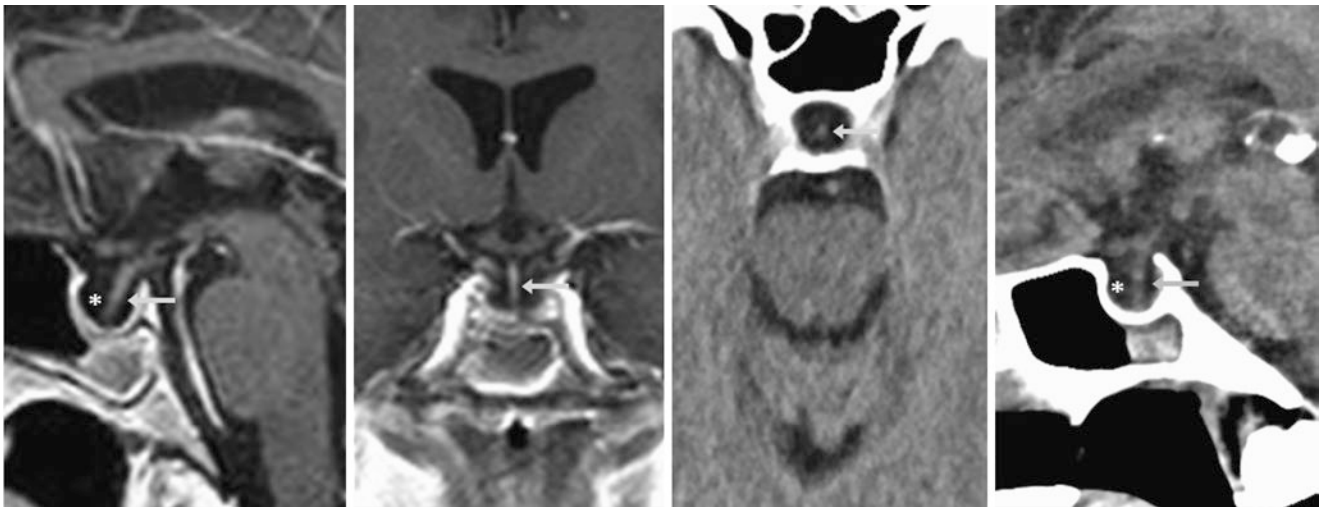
A 56-year-old female patient with confusion and an otherwise negative 1.5 T MRI had a completely empty PES (*). Note a normal stalk (*arrows*) on postcontrast sagittal (*left*) and coronal (*left middle*) T1WI. On CECT axial (*right middle*) and sagittal (*right*) reformats, the stalk is also visualized. Note that normal pituitary tissue is difficult to visualize
